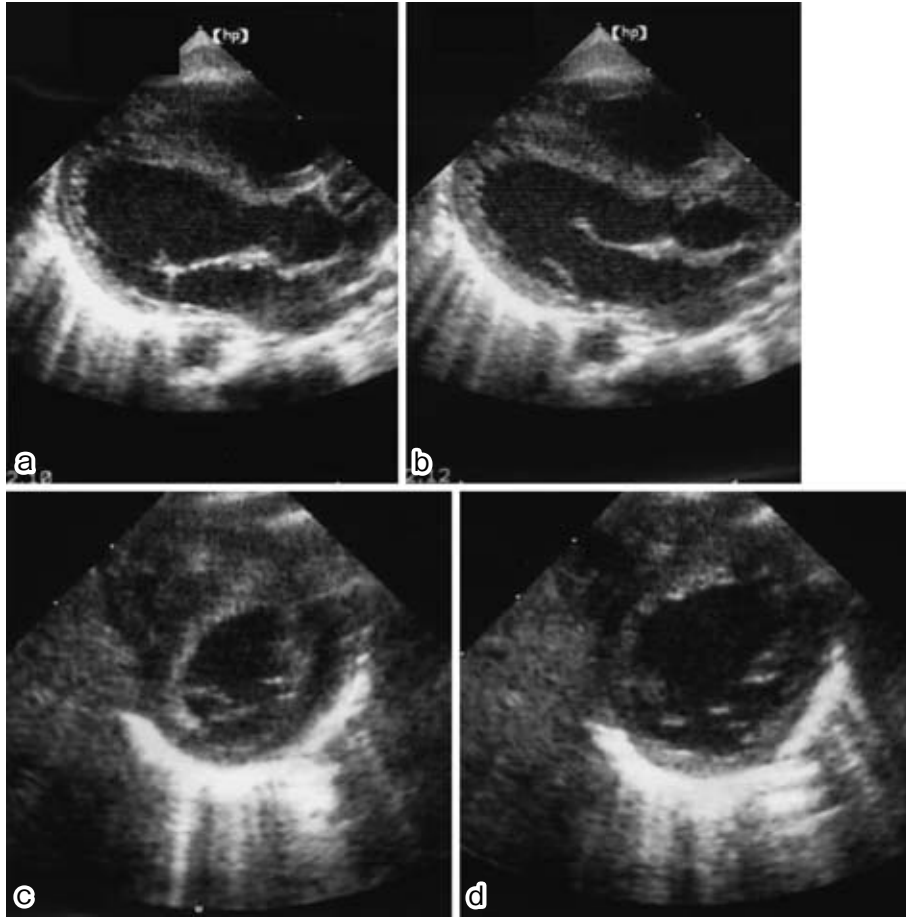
Two-dimensional echocardiographic view of the heart.
